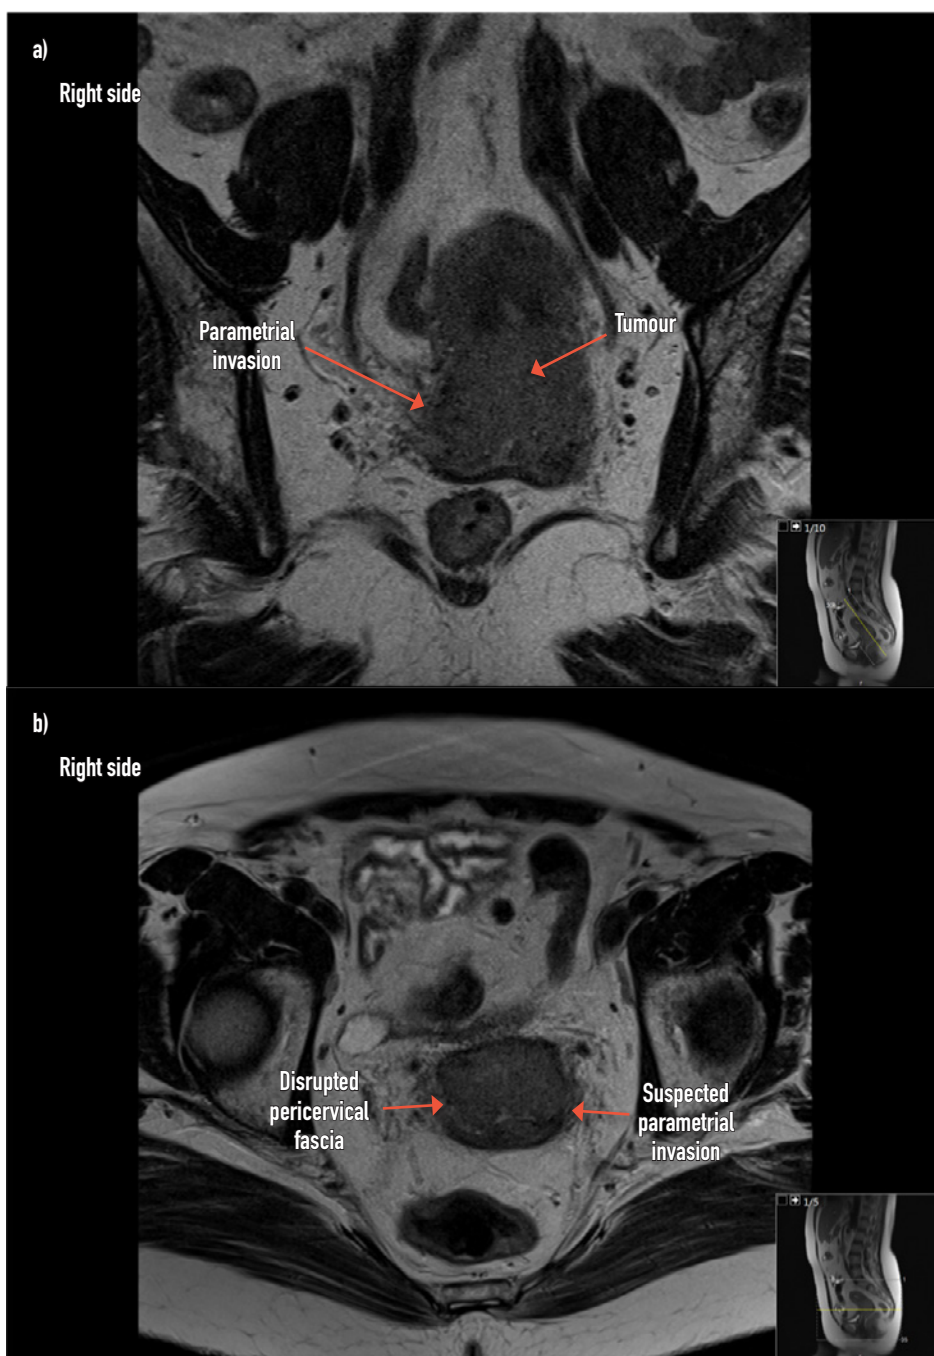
MRI for the same patient as featured in Figure 6, a woman with stage IIB cervical cancer. Figure a is from oblique coronary axis with arrow pointing at parametrial invasion on the patients right side, b is from transverse axial plane showing disrupted pericervical fascia to the right side and to the left also suspected minimal invasion to the parametrium. Images provided by: Susanne Fridsten.
